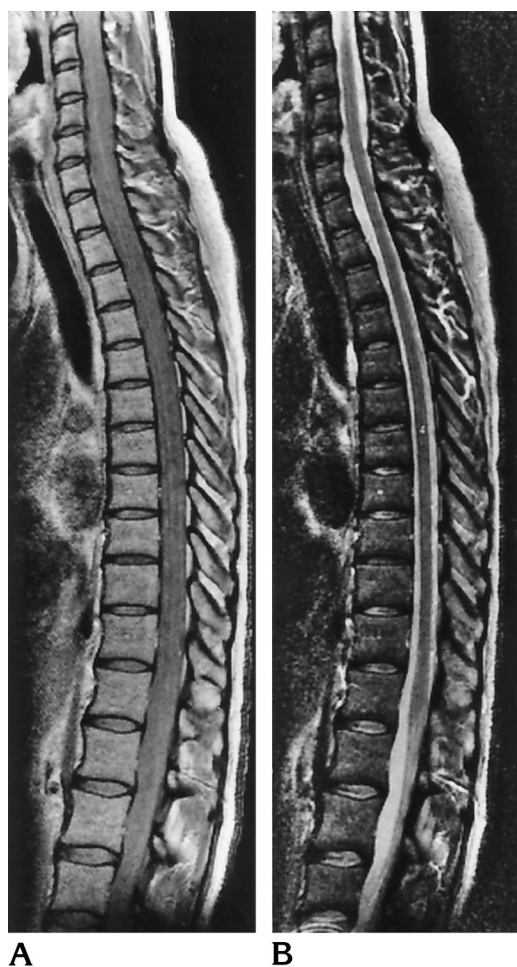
No abnormalities. Sagittal proton density-weighted (A) and T2-weighted (B) MR images (2200/20,80/1) of a healthy control subject show no lesions in the spinal cord. The spinal cord and the CSF have equal signal intensity on the proton density-weighted image.
